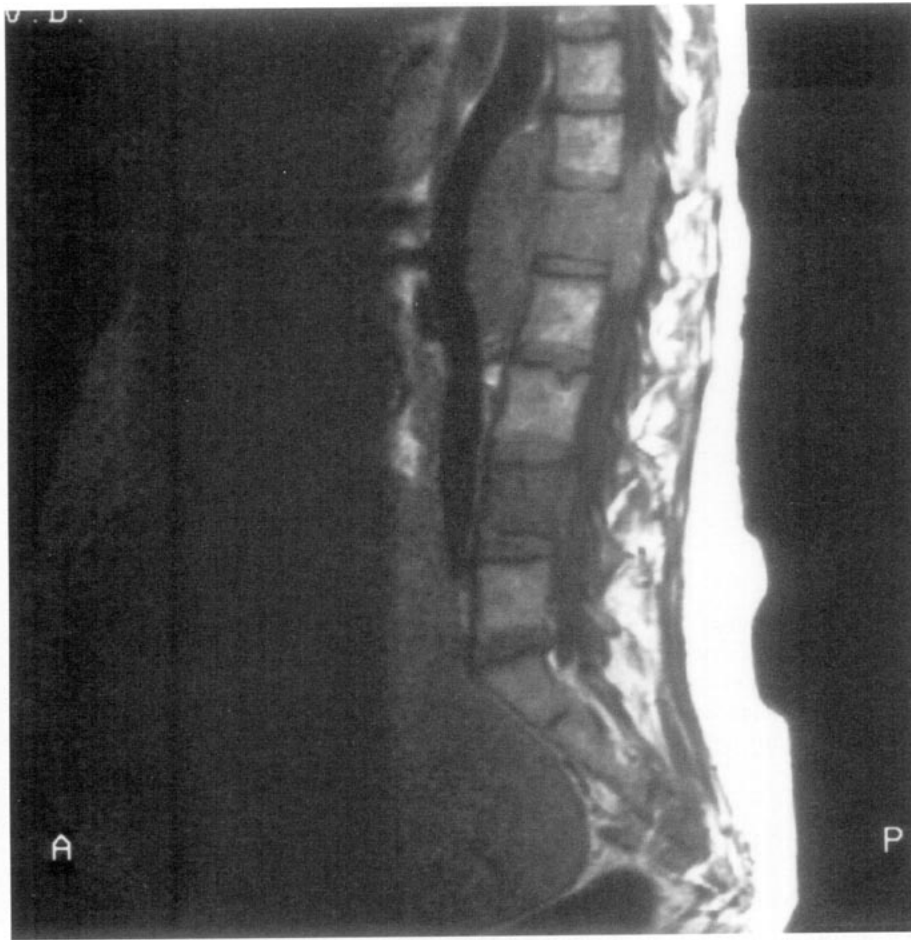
A T1-weighted SE image (TR500; TE25 at 0.5 T) shows a metastasis in L1 with extensive involvement of surrounding tissues including displacement of the aorta and epidural tumor. A second metastasis is seen in L4. (The lower sacral metastasis was better seen on different slices.)
